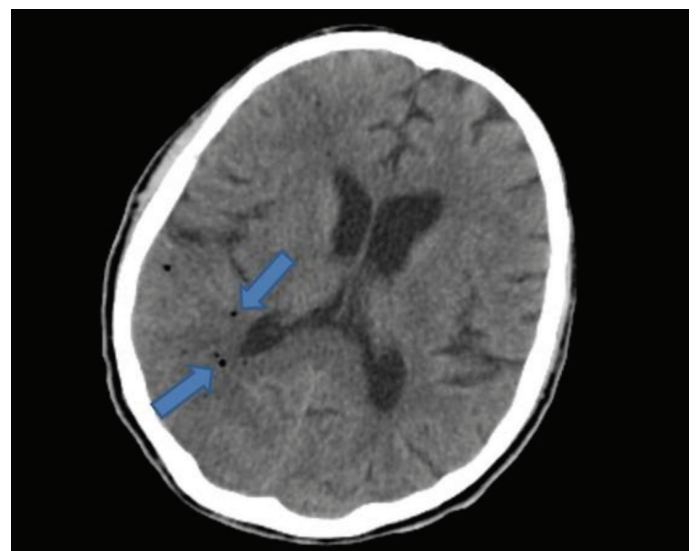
Arrows show cerebral air embolism on the right cerebral hemisphere in computed tomography imaging
